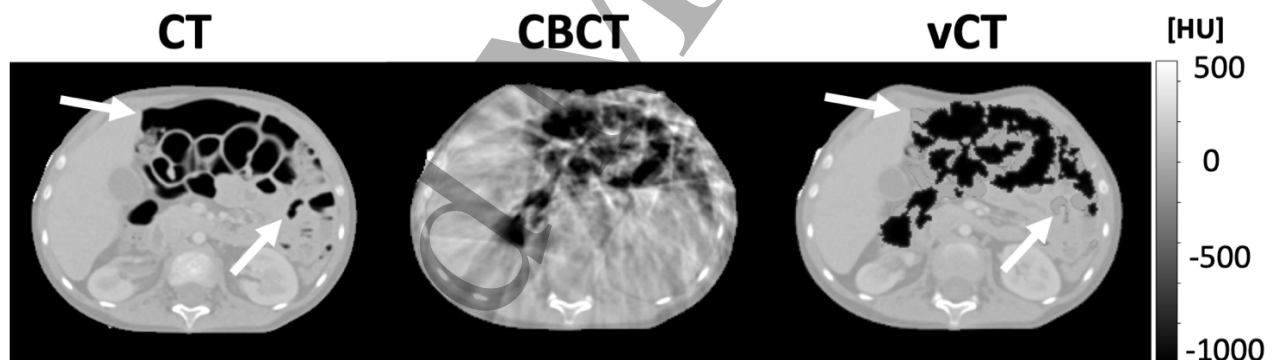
Example of paired CT, CBCT and virtual CT slices. The virtual CT was created by registering CT to CBCT and semi-automatically correcting for GI air differences. The air regions inside body in CT were replaced with water equivalent values prior to the registration, while air regions from CBCT were subsequently embedded into the virtual CT (that is indicated by white arrows in CT and in corresponding places in vCT).
